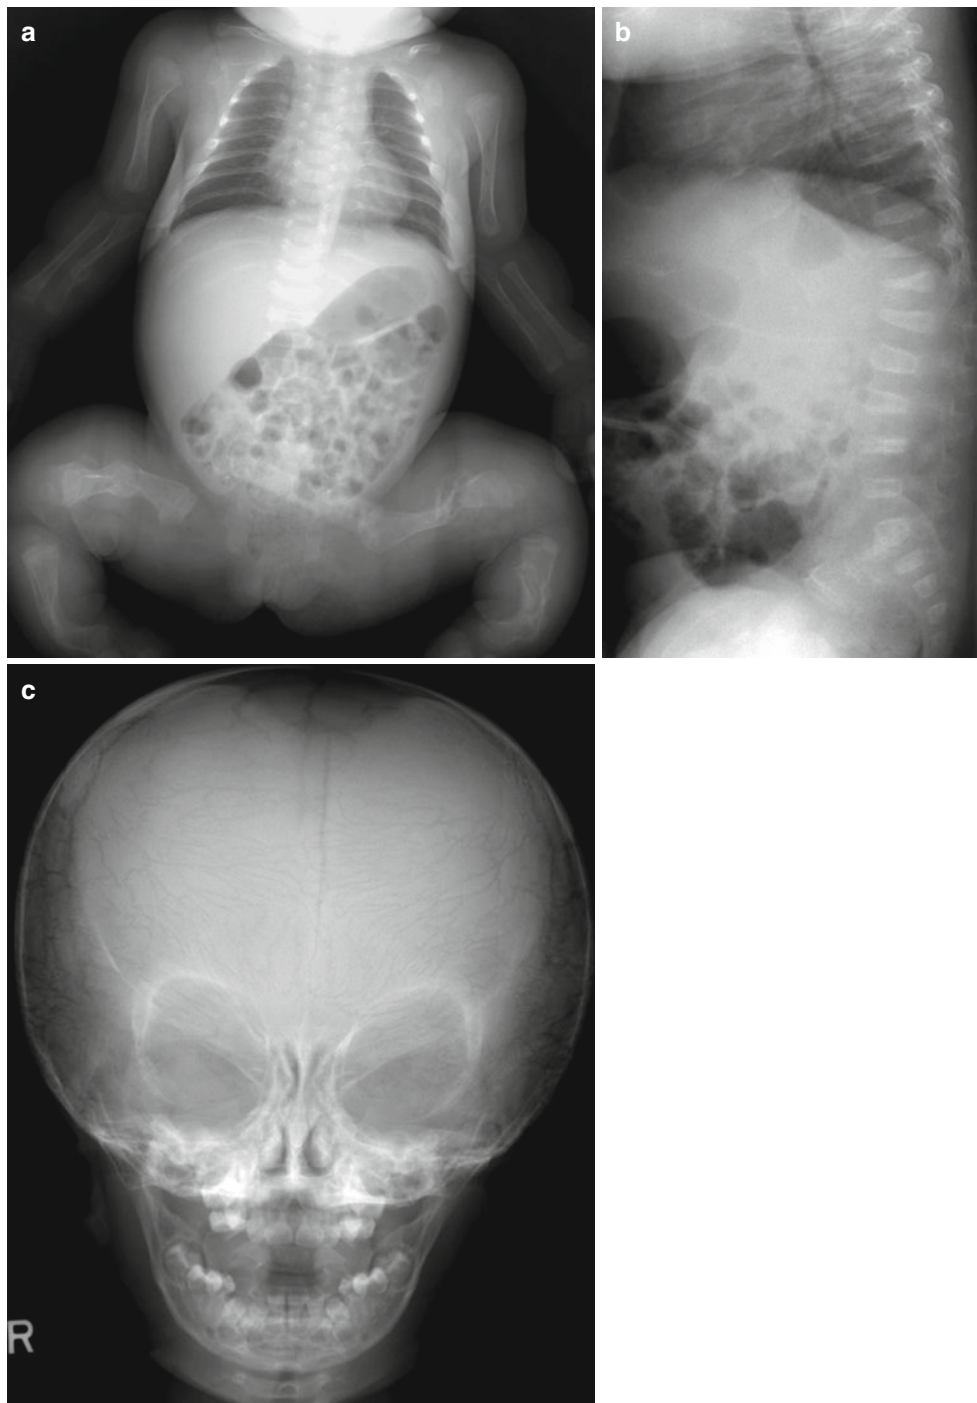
Osteogenesis imperfecta: newborn.* (a–b) Anteroposterior radiograph and spine lateral radiograph show multiple fractures in the long tubular bones and flat vertebral bodies. There is a generalized
